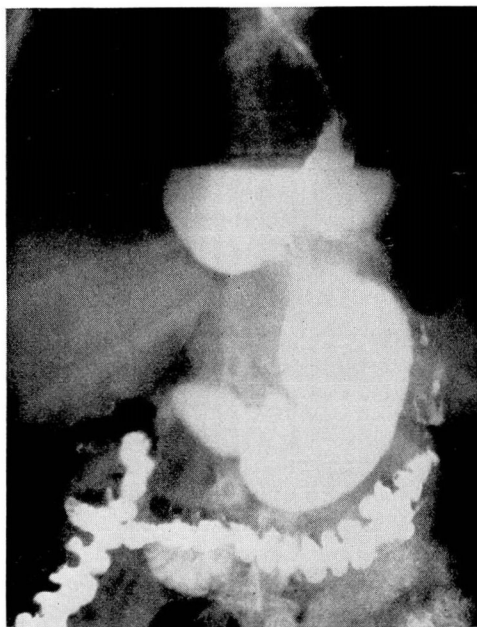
Large esophageal hiatus hernia. Esophagus displaced anteriorly, still well-outlined by the contrast medium. Herniated portion of stomach partially incarcerated and incompletely obstructed. Patient complained of regurgitation following each meal and nocturnal retrosternal pain. Symptoms completely removed by transthoracic repair of hernia.
